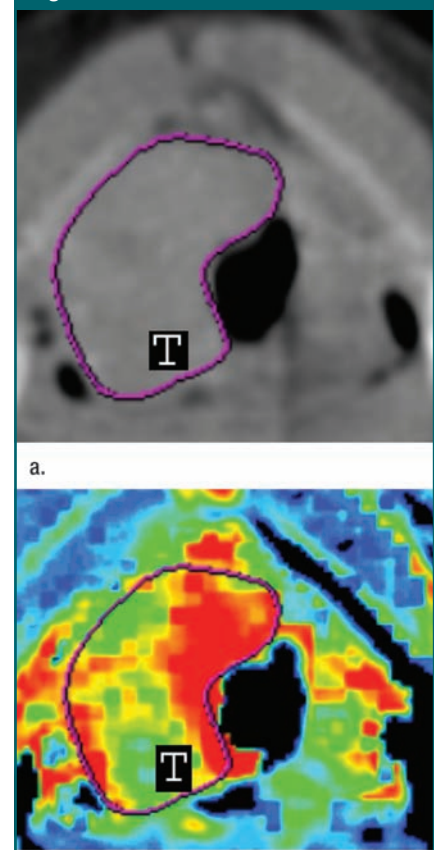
(a) Contrast-enhanced neck CT scan in 45-year-old man with stage IV squamous cell carcinoma in the base of the tongue. A solid mass (*T*) is localized at the right tongue base, through its largest cross-sectional area. (b) CT perfusion map shows maximal ROI used to obtain perfusion parameters such as BF in this case. This tumor (*T*) demonstrated elevated BF (190.15 mL/100 g/min), and endoscopic biopsy results revealed relative increased intratumoral MVD (47.2 vessels per square millimeter).
